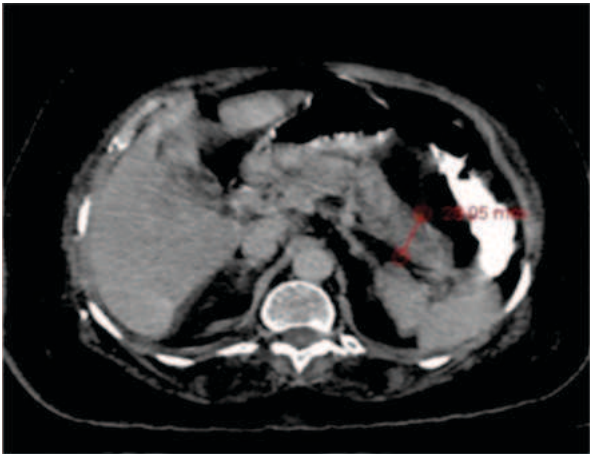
Axial contrast-enhanced computed tomography scan of a 45-year-old male patient with diffuse pancreatic parenchymal enlargement predominantly affected the body and tail with decreased attenuation. Indistinct pancreatic margins with surrounding retroperitoneal fat stranding. Few peripancreatic and periportal lymph nodes noted.
